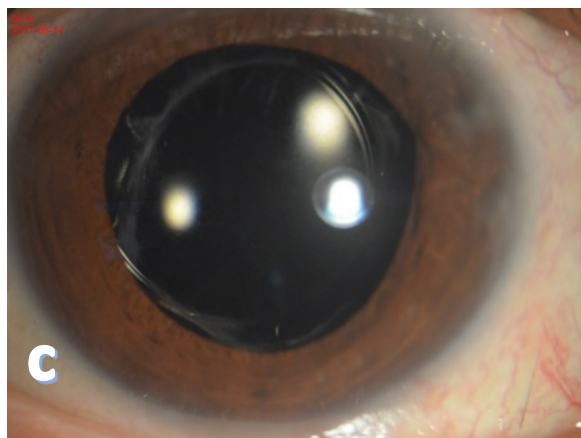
Anterior segment of the right eye after surgery and IOL implant. B ultrasound of the right eye indicates that the vitreous blood is cleared.
